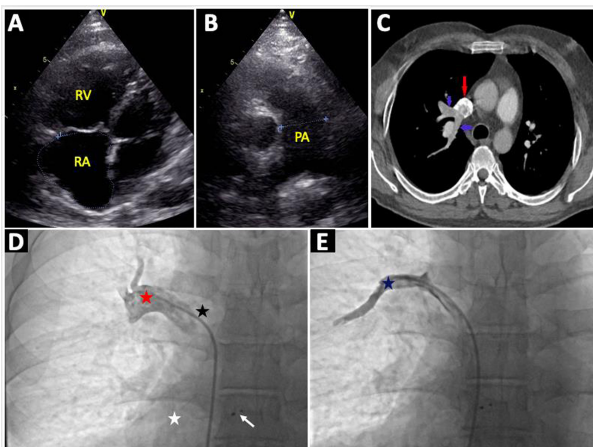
Figure A, Transthoracic echocardiography apical four chamber view (dilated right heart chamber, RA area 21.6 cm²) Figure B, Transthoracic echocardiography short axis view (dilated pulmonary artery with diameter 3.2 cm) Figure C, Axial computed tomography pulmonary angiography section shows that right upper pulmonary veins (blue arrows) are draining to superior vena cava (red arrow) Figure D, Angiographic images of right upper pulmonary vein (red asterics) drain to superior vena cava (blue asterics) with an enlarged root of approximately 2 cm (White asterics: right atrium, White arrow: Atrial septal defect occluder device) Figure E, Angiographic images of right upper pulmonary vein (blue asterics) drain to superior vena cava RA: right atrium, SVC: superior vena cava
